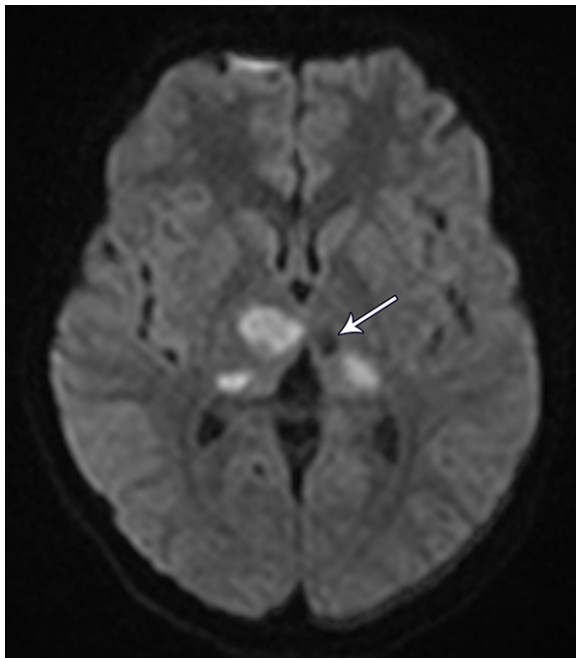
Infarcts of varying ages due to VAD in a 12-year-old girl. Axial diffusion-weighted MR image shows acute infarcts within both thalami, with low diffusivity confirmed on apparent diffusion coefficient maps (not shown). A chronic lacunar left thalamic infarct (arrow) does not show low diffusivity. Infarcts of different ages seen at initial imaging are common in VAD.
